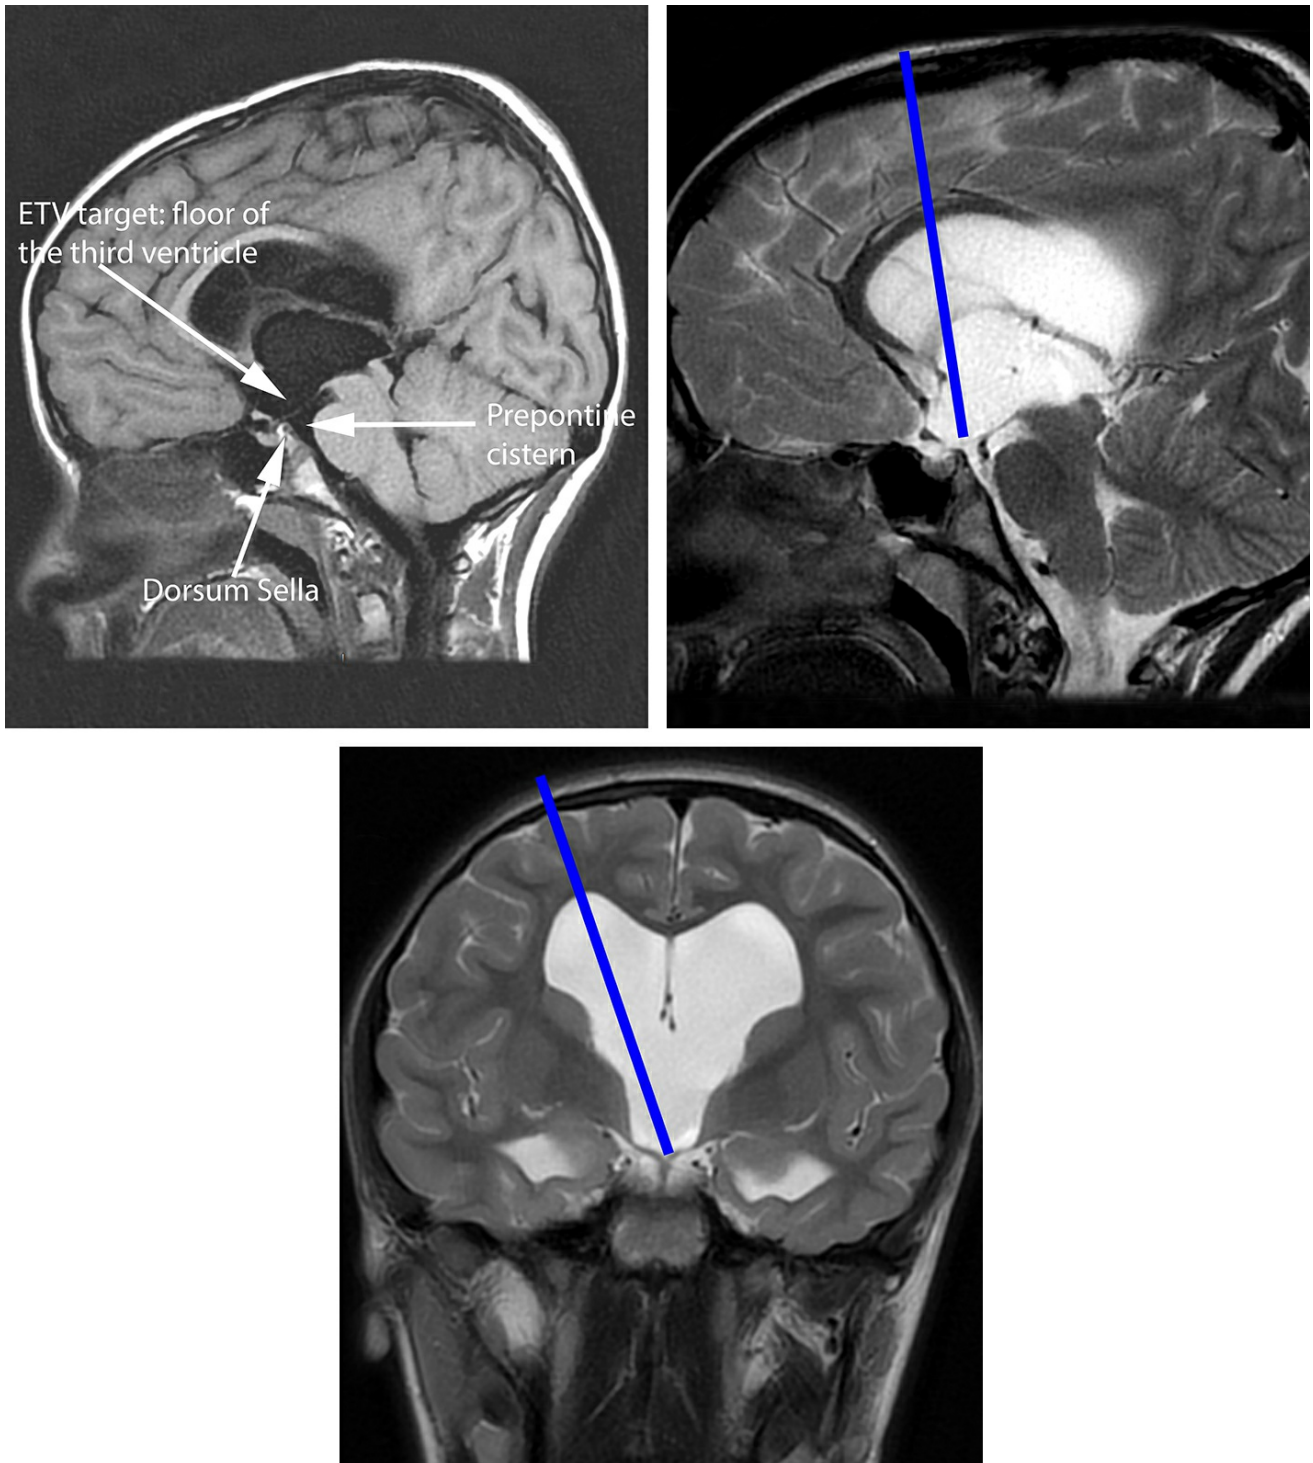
(Top Left) Sagittal T1-weighted MRI of a patient considered for
